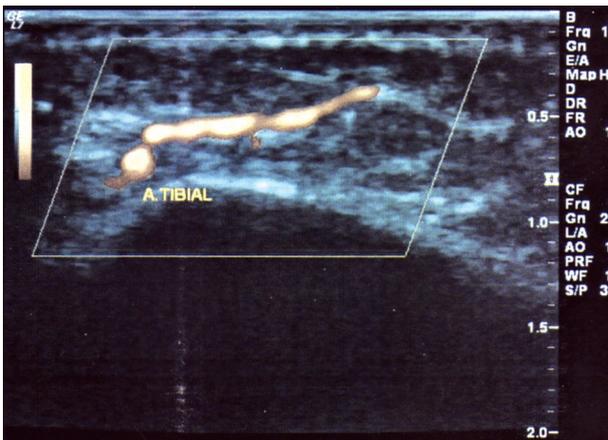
Location of anterior tibial artery and the perforator arising from it using power Doppler mode.
